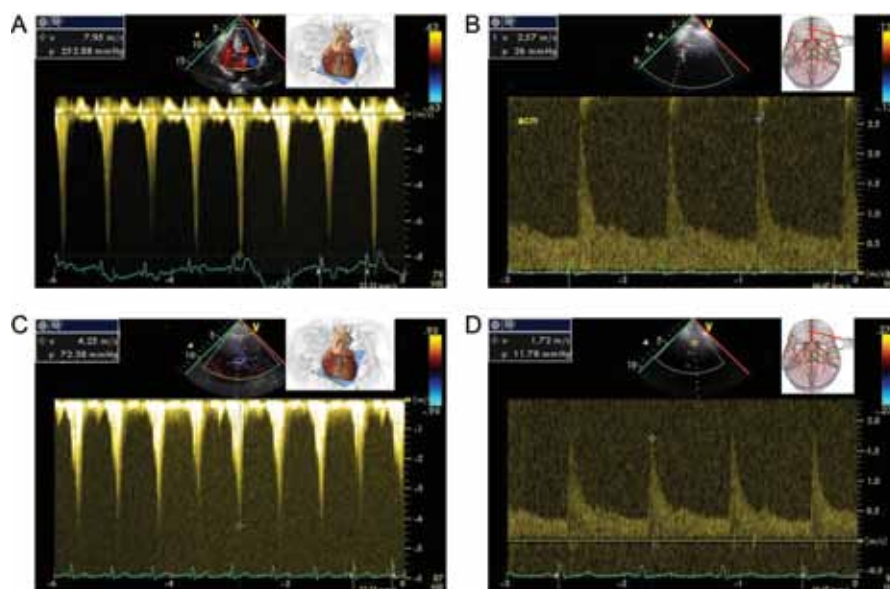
Left ventricular outflow tract (LVOT) obstruction. A 31-year-old man with subarachnoid haemorrhage receiving intravenous milrinone develops LVOT obstruction. (A) Note the significant pressure gradient (252 mmHg) and velocities (7.9 m/s) across the LVOT obtained using an apical five-chamber view. (B) The associated transcranial Doppler velocities of the right middle cerebral artery (MCA) were 2.57 m/s. (C,D) Following a bolus of 500mL of crystalloid, (C) the LVOT gradient drops to 72 mmHg and (D) the right MCA velocity decreases to 1.72 m/s.
